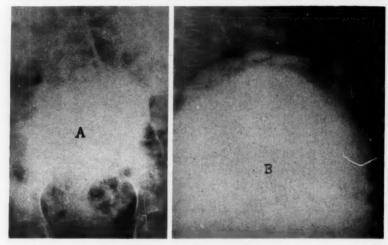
Roentgenograms of abdomen-note dense tumor masses.
